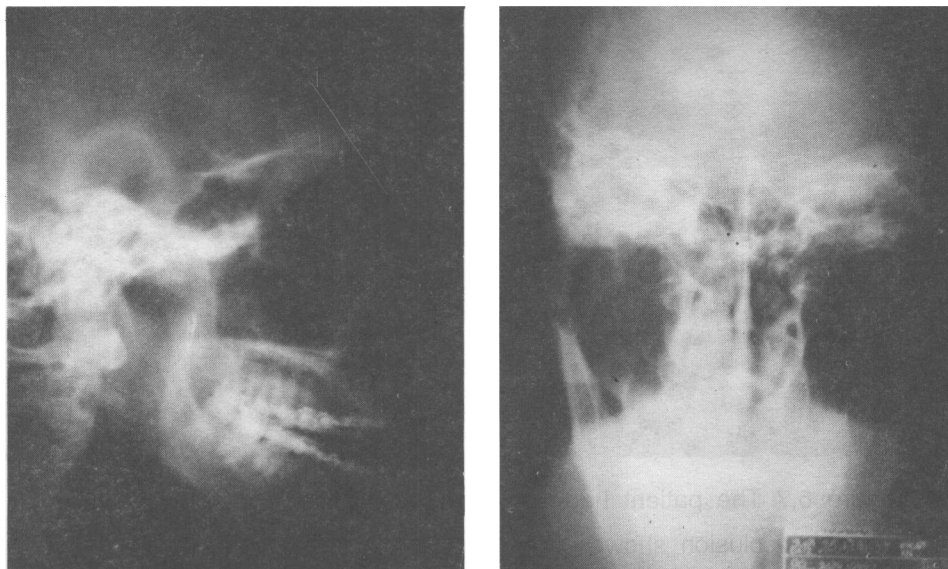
5 Postoperative x-ray show the fixed fracture segments in anatomical position
